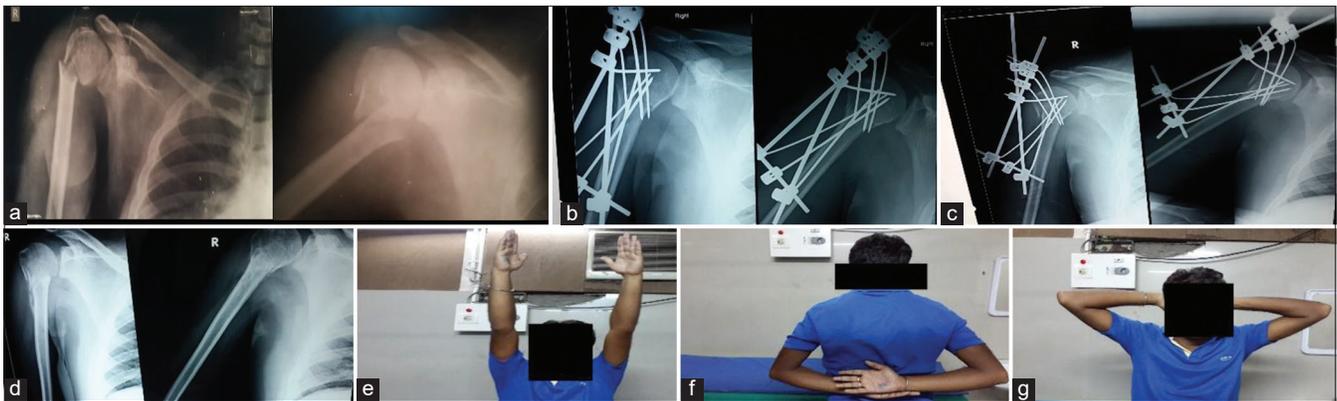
(a) Case 2 – 23 years male pre-operative X-ray AP/lat, (b) Case 2 – immediate after post-operative X-ray, (c) Case 2 – 4 weeks after post-operative X-ray, (d) Case 2 – X-ray after implant removal, (e) Case 2 – final ROM elevation, (f) Case 2 – final ROM extension, (g) Case 2 – final ROM external rotation
